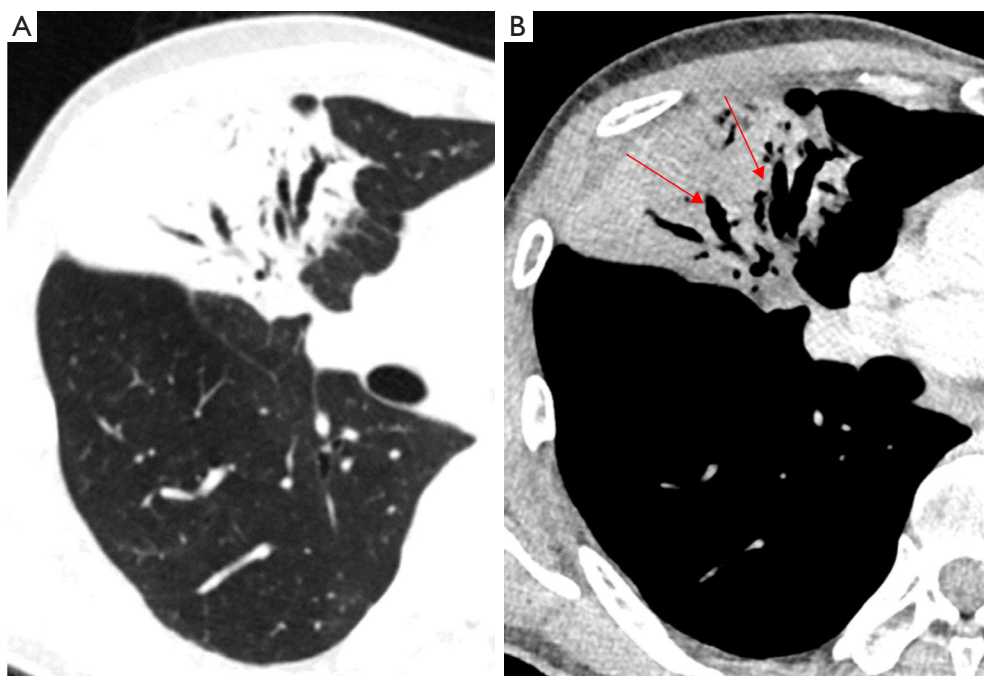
Pulmonary MALT lymphoma. M, 51 y/o; symptoms: a low fever and right chest pain for 5 days. (A,B) CECT showed consolidation in the middle lobe of the right lung, moderate uniform enhancement, the air bronchial sign (type II, as indicated by the arrows), and fusiform aneurysmal dilation of the lumen. MALT, mucosa associated lymphoid tissue; M, male; y/o, years old; CECT, contrast-enhanced computed tomography.
